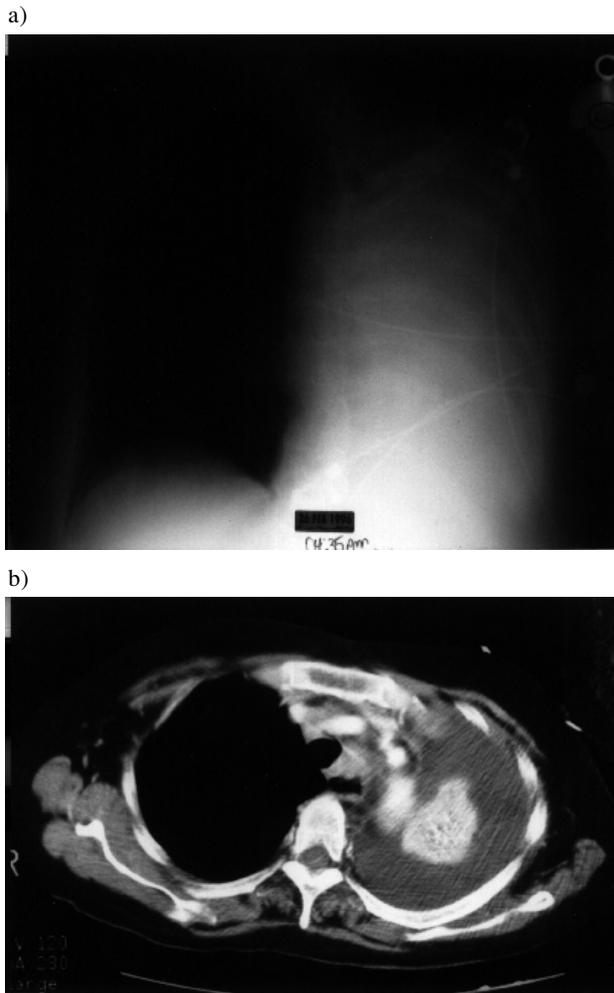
a) Chest radiograph reveals opacification of the left hemithorax with mediastinal shift suggesting atelectasis. The left main bronchus was obstructed by a small cell carcinoma. b) Computed tomography (CT) scan just above the level of the carina reveals the atelectatic lung surrounded by a large *ex-vacuo* pleural effusion. Thoracentesis obtained transudative fluid, which did not contain any malignant cells.
